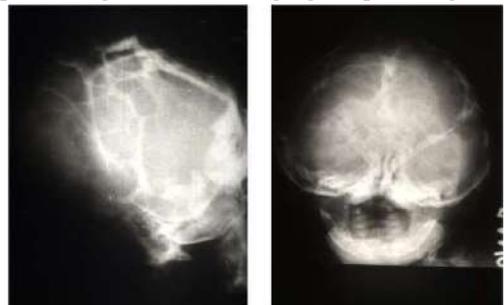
X-ray — Cranio-lacunae & Cloverleaf skull
